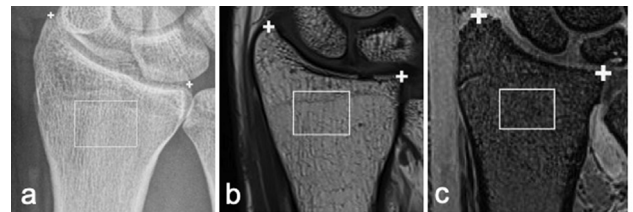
Examples of region of interest (ROI) placement on radiography (a), T1-TSE (b) and T1-VIBE (c) coronal MR images. The ROIs are automatically generated after manual placement of 2 points consisting of the distal radial styloid and the ulnar/distalmost aspect of the radius.
